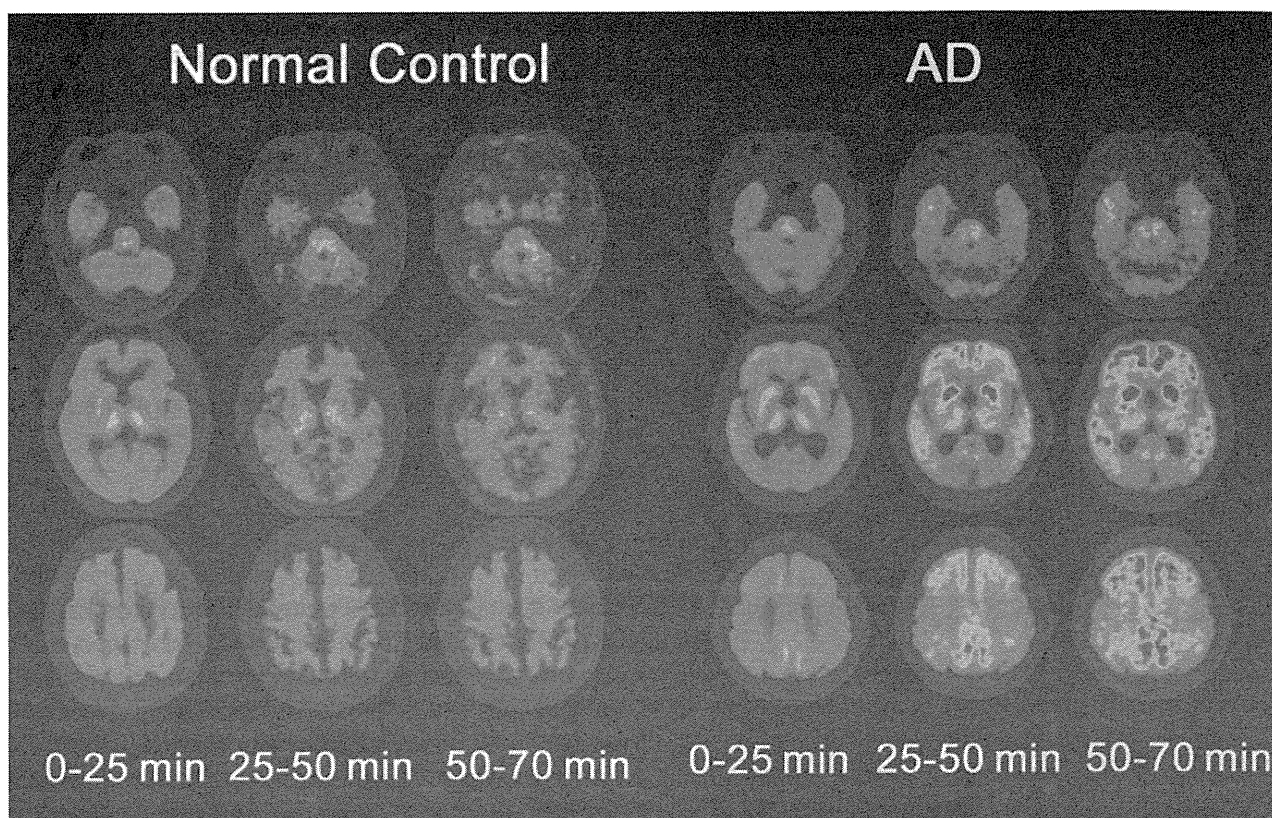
SUVR images for the periods 0 to 25 minutes, 25 to 50 minutes, and 50 to 70 minutes for a control subject and a patient with AD. Note temporal changes in PiB distribution. The main factors determining PiB distribution changed from perfusion in an early phase to deposition in A $\beta$  in a late phase. A control individual shows no accumulation in cerebral cortex but nonspecific accumulation in white matter in the late phase (PiB-negative). A patient with AD shows prominent PiB accumulation in the entire cerebral cortex except for occipital cortex and striatum in the late phase (PiB-positive). The cerebellar cortex shows very low accumulation in the late phase.
